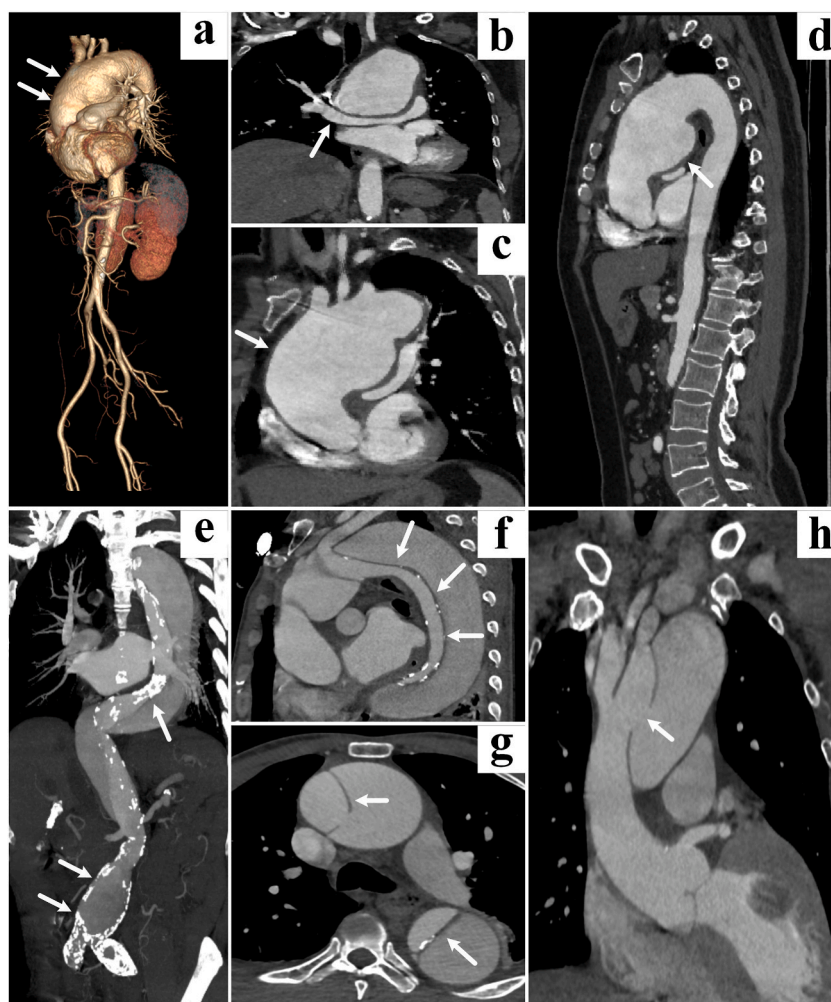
Case Studies of Aortic Pathologies Using CT Angiography (CTA)
